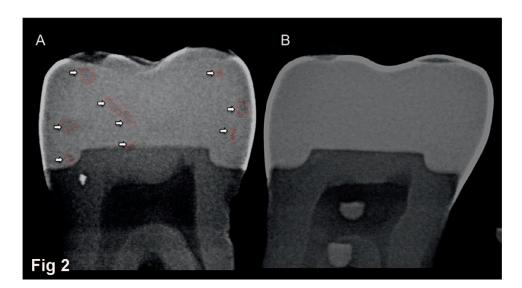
Amplified radiographs of restorative techniques to detect and measure the voids. (A): tooth with several voids. (B): tooth without voids.
